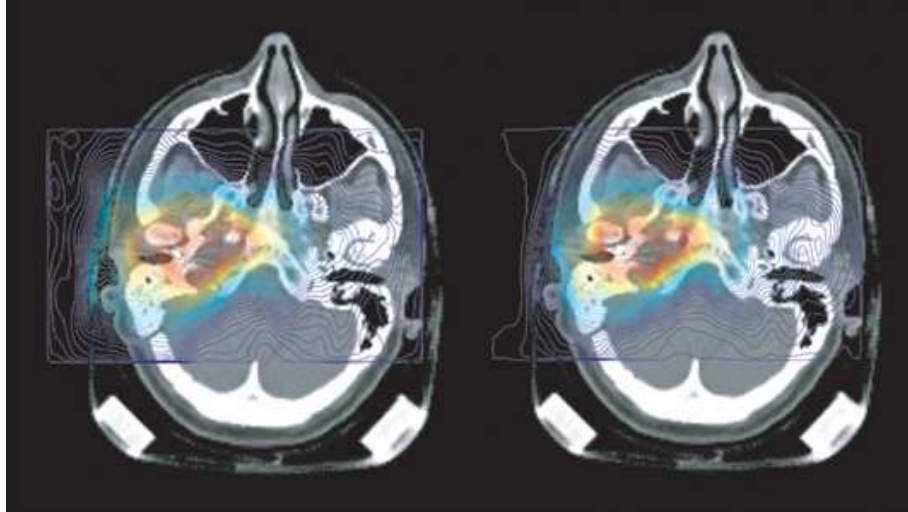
The PET analysis visualizes the irradiation inside the patient. From the doseplanning, a distribution of positron activity can be predicted (left). The figure on the right shows the measured positron activity during irradiation. Both PET images have been projected onto a CT-picture. By comparing the two images, it can be confirmed whether or not the planned dose distribution was achieved [13].
